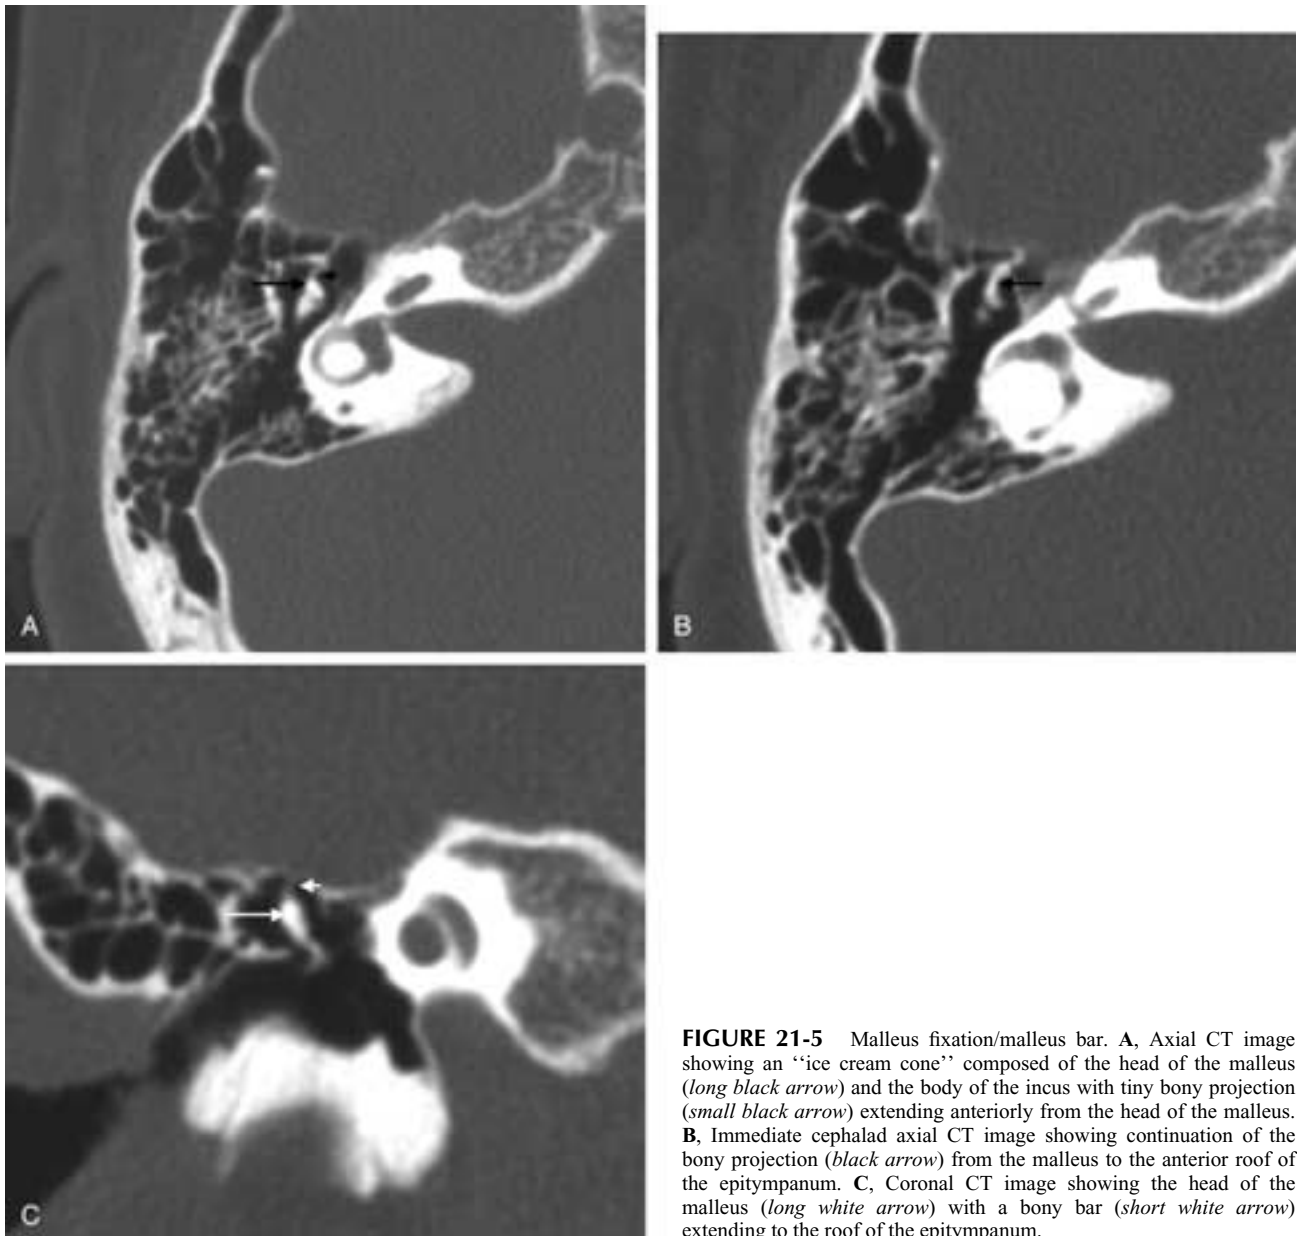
Malleus fixation/malleus bar. A, Axial CT image showing an “ice cream cone” composed of the head of the malleus (*long black arrow*) and the body of the incus with tiny bony projection (*small black arrow*) extending anteriorly from the head of the malleus. B, Immediate cephalad axial CT image showing continuation of the bony projection (*black arrow*) from the malleus to the anterior roof of the epitympanum. C, Coronal CT image showing the head of the malleus (*long white arrow*) with a bony bar (*short white arrow*) extending to the roof of the epitympanum.
